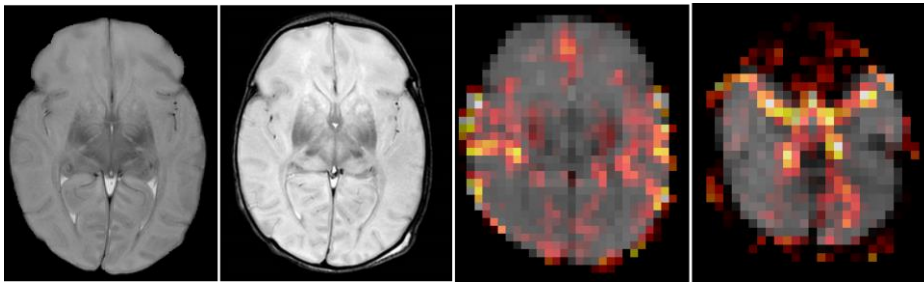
MRI and rCBF maps from infant ID18. T2 MRI: NICHD scoring 3, severe oedema and devastating brain lesions. rCBF maps: low brain perfusion with “labelled” blood in the large arteries of the circle of Willis.
